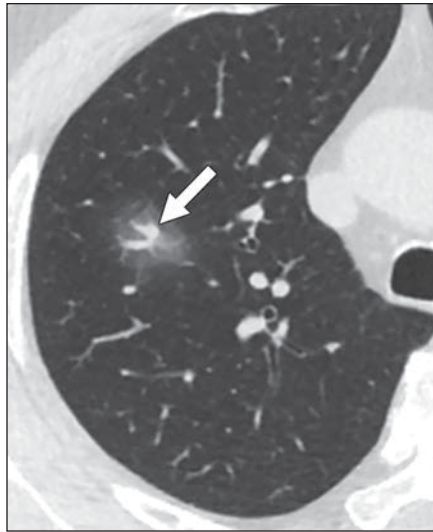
CT features indicating changes in lungs caused by coronavirus disease 2019 pneumonia in eight patients.
